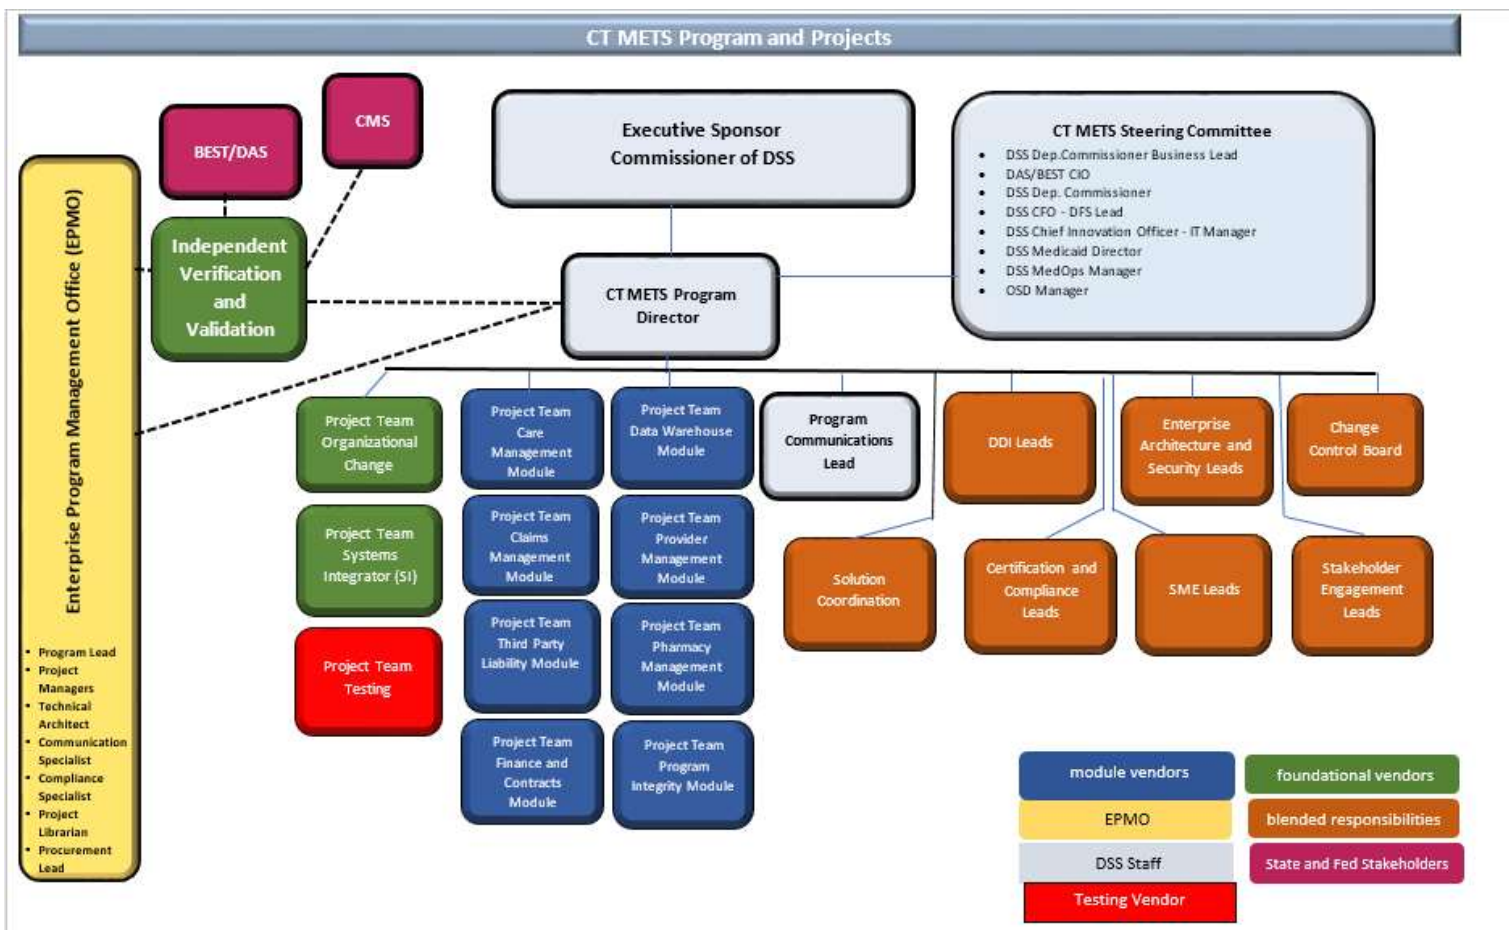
Current CT METS Governance Structure
